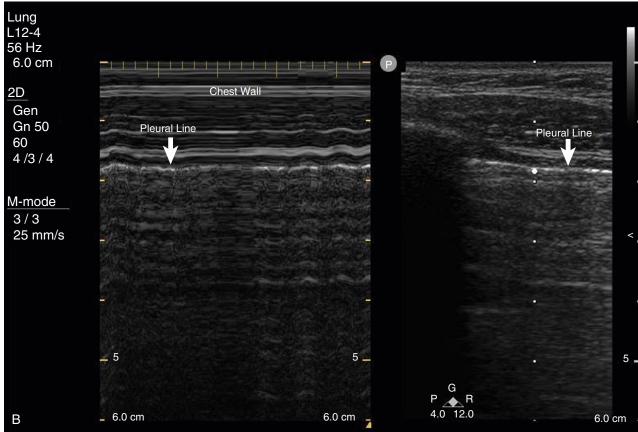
(A) Ultrasound demonstrating location of pleural line. Lung sliding is dynamic and visualized in real time as shimmering or sliding of the pleural line. (B) The use of M-mode creates a "seashore" sign with normal lung sliding.
